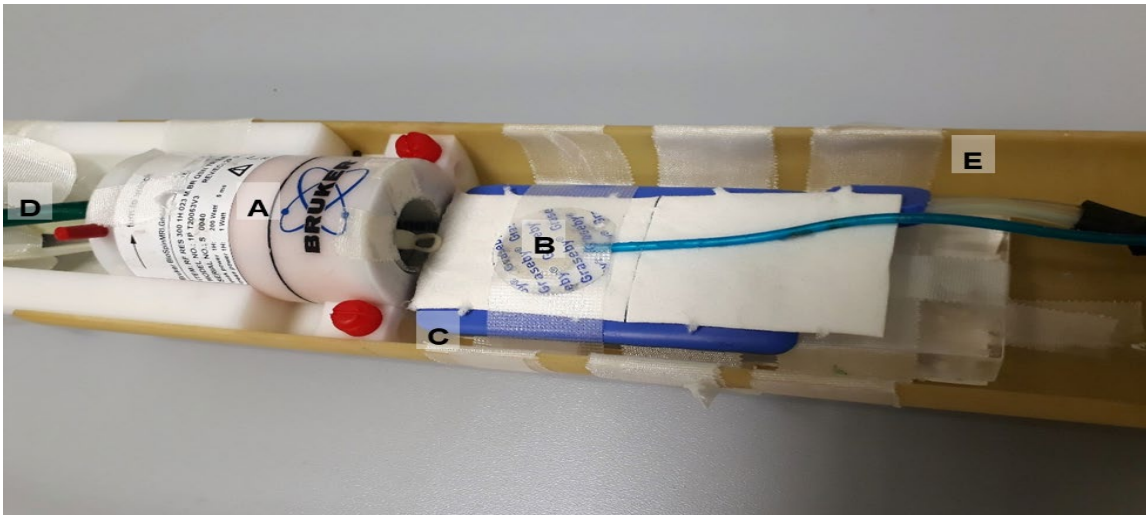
MRI measurement setup
